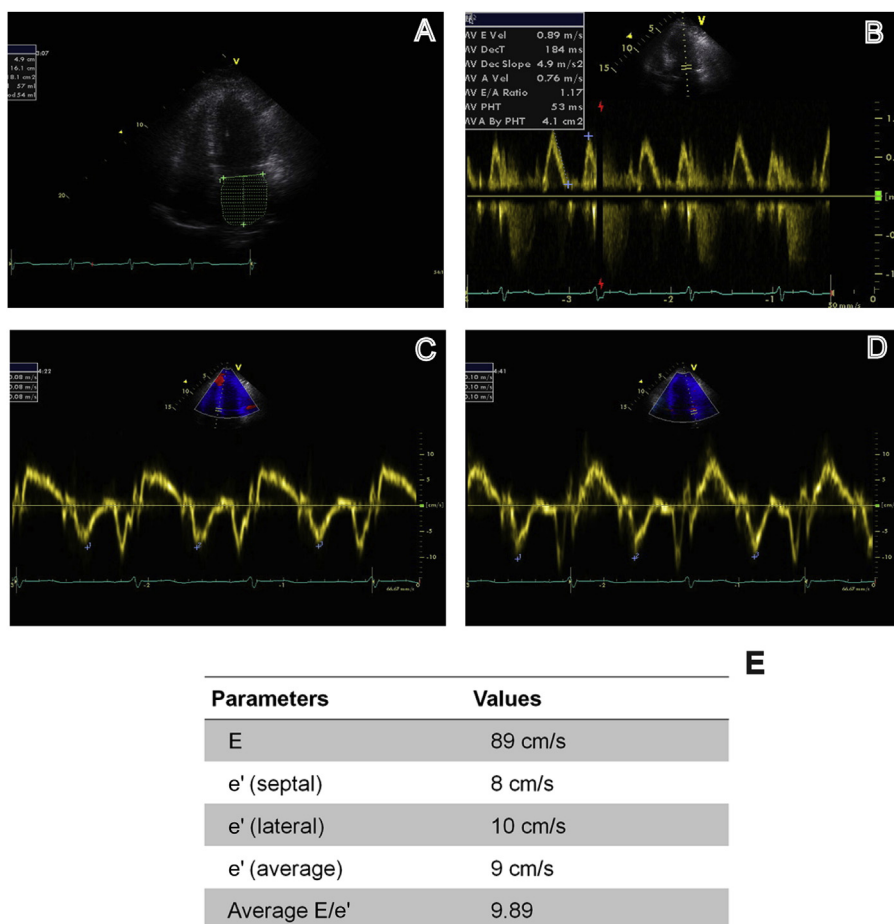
An example of images captured from an end-stage renal disease patient (49-year-old male) with low E/e' ratio. (A) End-systolic left atrial (LA) volume with a volume index of 28.6 mL/m² was acquired in the apical four-chamber view. LA volume = 54 mL; body surface area = 1.89 m². (B) Pulsed-wave Doppler, and (C, D) tissue Doppler were performed in the apical four-chamber view to acquire mitral inflow early diastolic velocity (parameter E), septal, and lateral tissue Doppler signals (e') of the mitral annulus. Average septal e' = 8 cm/s; average lateral e' = 10 cm/s. (E) Echocardiography parameters: the average (septal and lateral) e' velocity was used to calculate the E/e' ratio.
